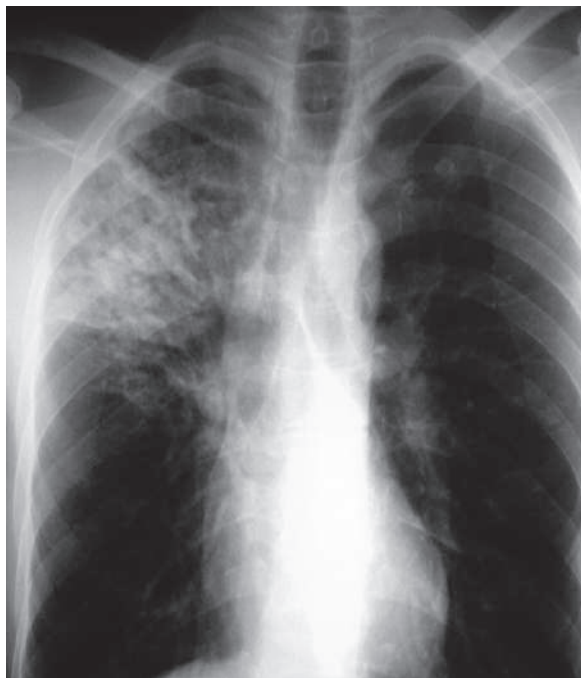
Posteroanterior plain chest radiograph in a TB patient shows right apical fibrosis (Simon's focus)
